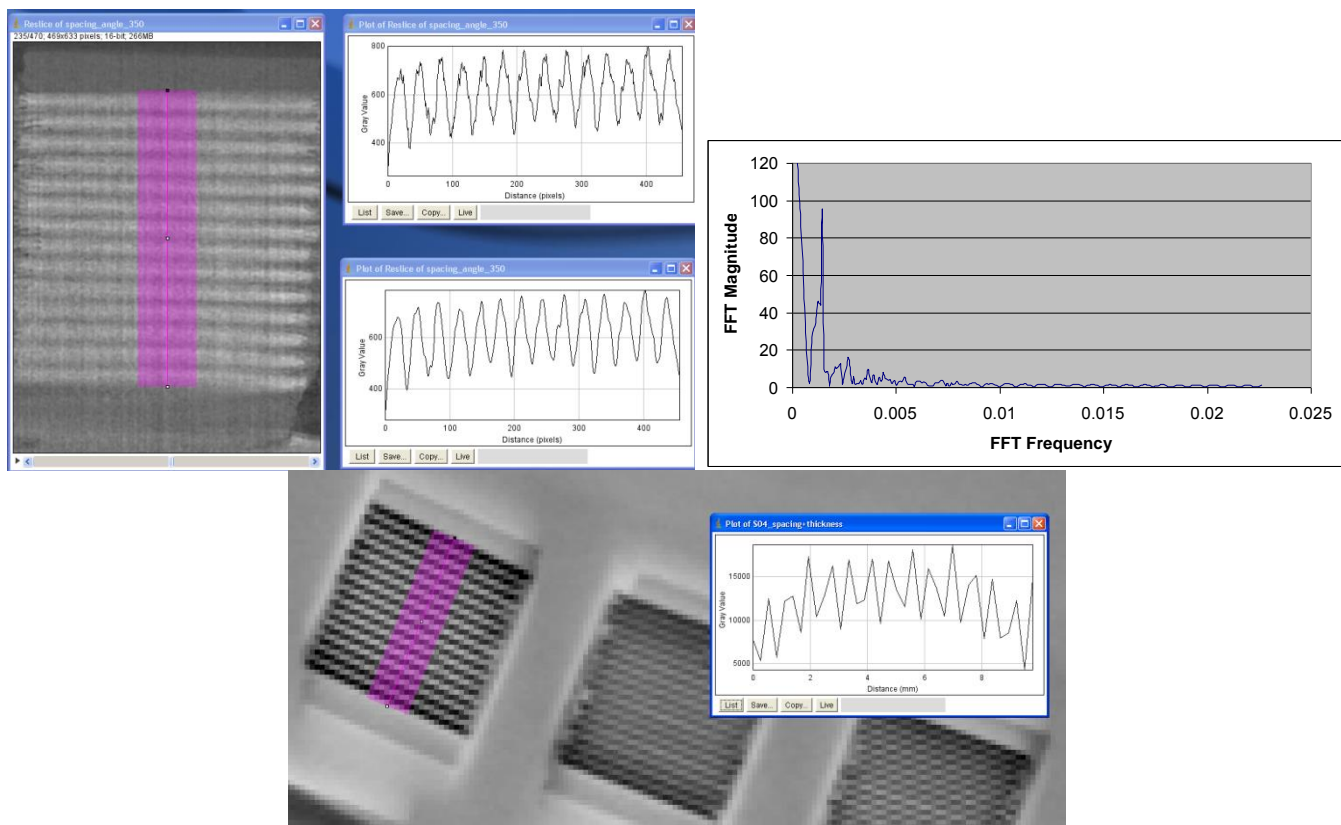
Creating line profile for Fast Fourier Transform from filtered μ CT reconstruction (upper left). In the above plot, a peak was identified at 351.23 μ m (upper right). The same procedure was repeated for DTS images (bottom center).
